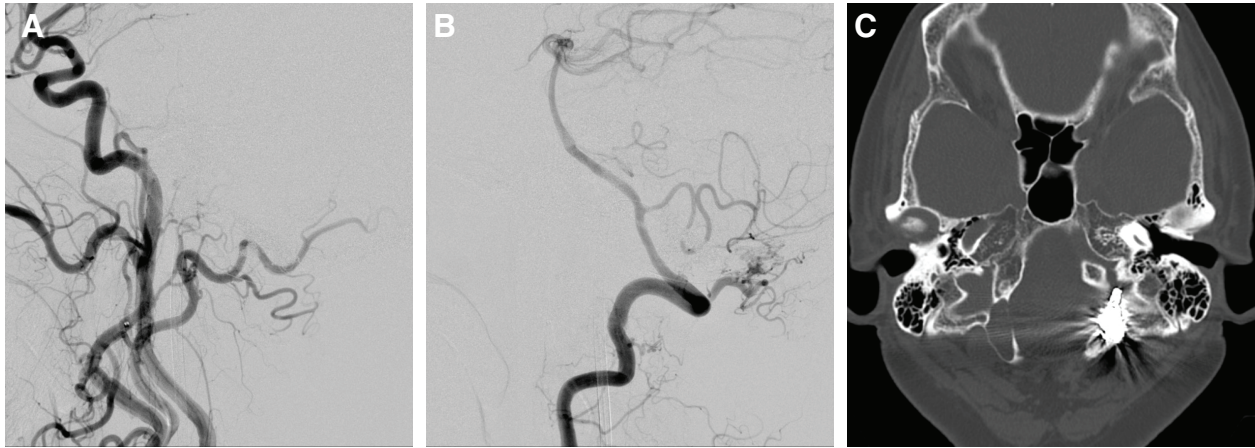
(A, B) Lateral view on angiography of the left CCA and VA. The AV shunt and patient's symptom disappeared after occluding the PCV from the osseous shunt. (C) Postoperative CT showed the coil
